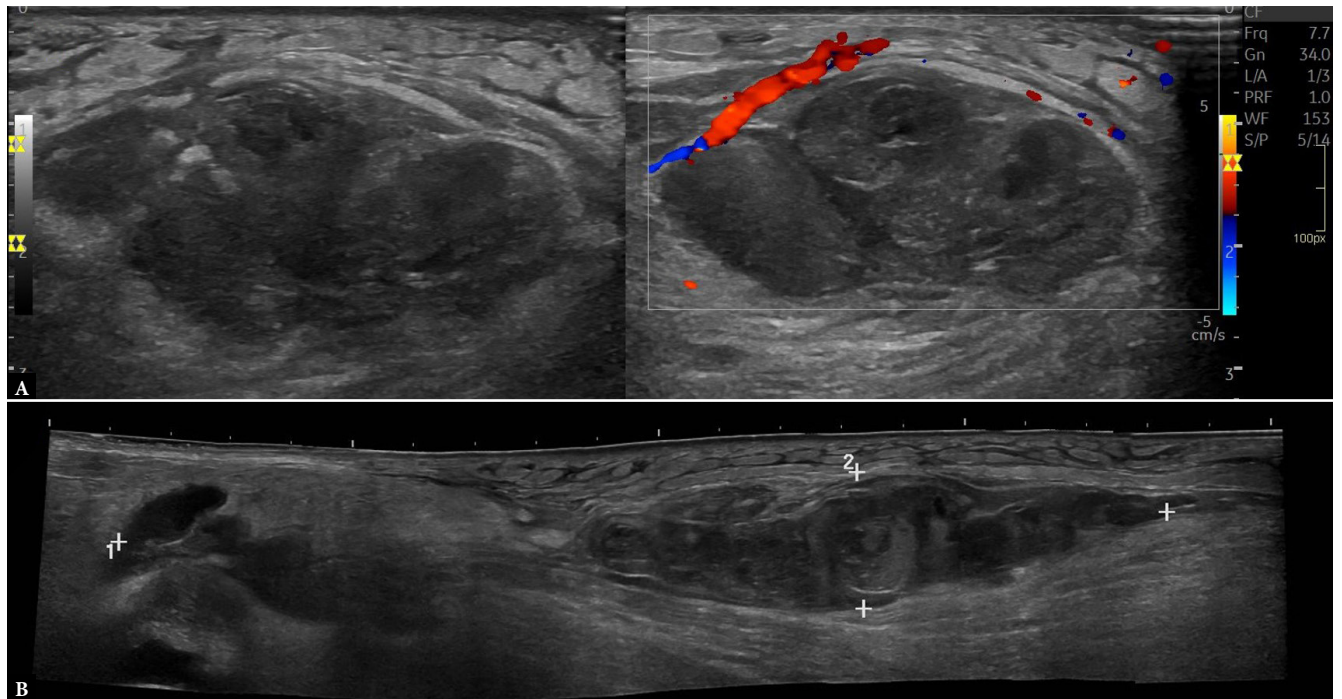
Ultrasound examination of the posterior medial calf demonstrating a large, inhomogeneous hypoechoic fluid collection (17 × 4 × 2 cm) extending proximally toward the popliteal fossa (A), without internal vascular signal on CD imaging (B). Findings are consistent with a ruptured Baker's cyst with associated surrounding subcutaneous edema
